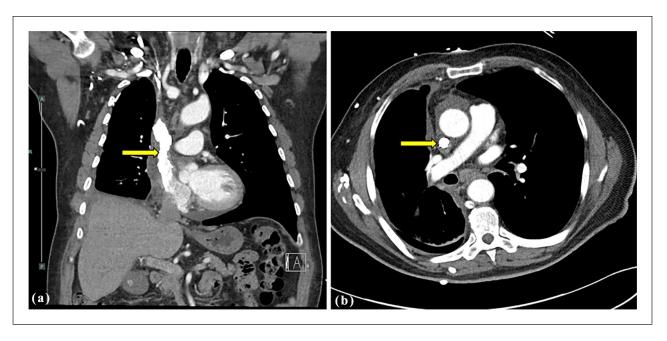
Post-intervention coronal and axial CT angiogram demonstrates a patent stent with significant interval improvement in bilateral pleural effusions (demonstrated by the arrows in (a, b)). CT: computed tomography.
